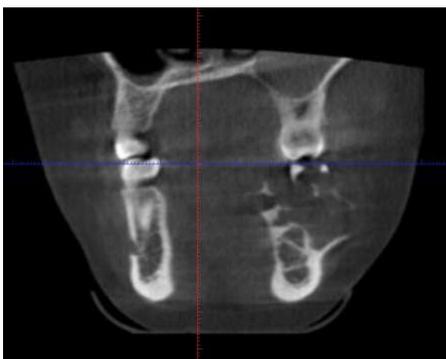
CBCT showed multiple thin, straight septae within the radiolucent lesion.
